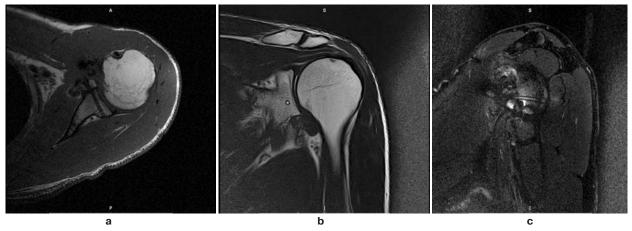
Patient S. MRI of left shoulder joint in 6 months after the surgery: a – axial; b – frontal; c – lateral.
